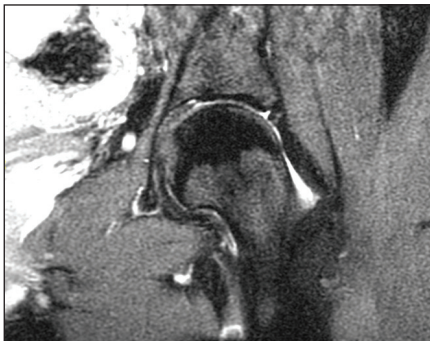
Preoperative magnetic resonance image of Patient 3 showing an acetabular labral tear.
